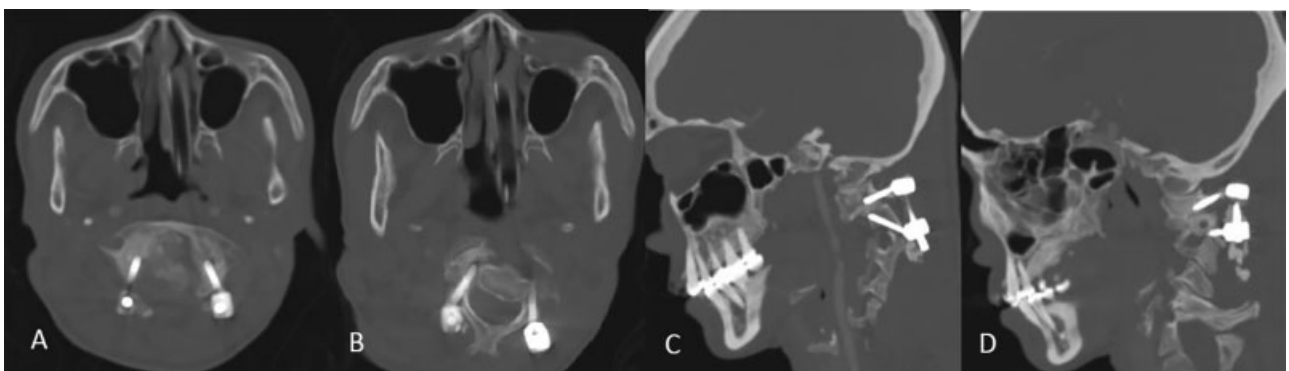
Postoperative CT of first patient. (A) Screws of C1. (B) Screws of C2. The right C2 pedicle screw has malposition. (C) Sagittal view of left side screws. (D) Sagittal view of right side screws. CT, computed tomography.
